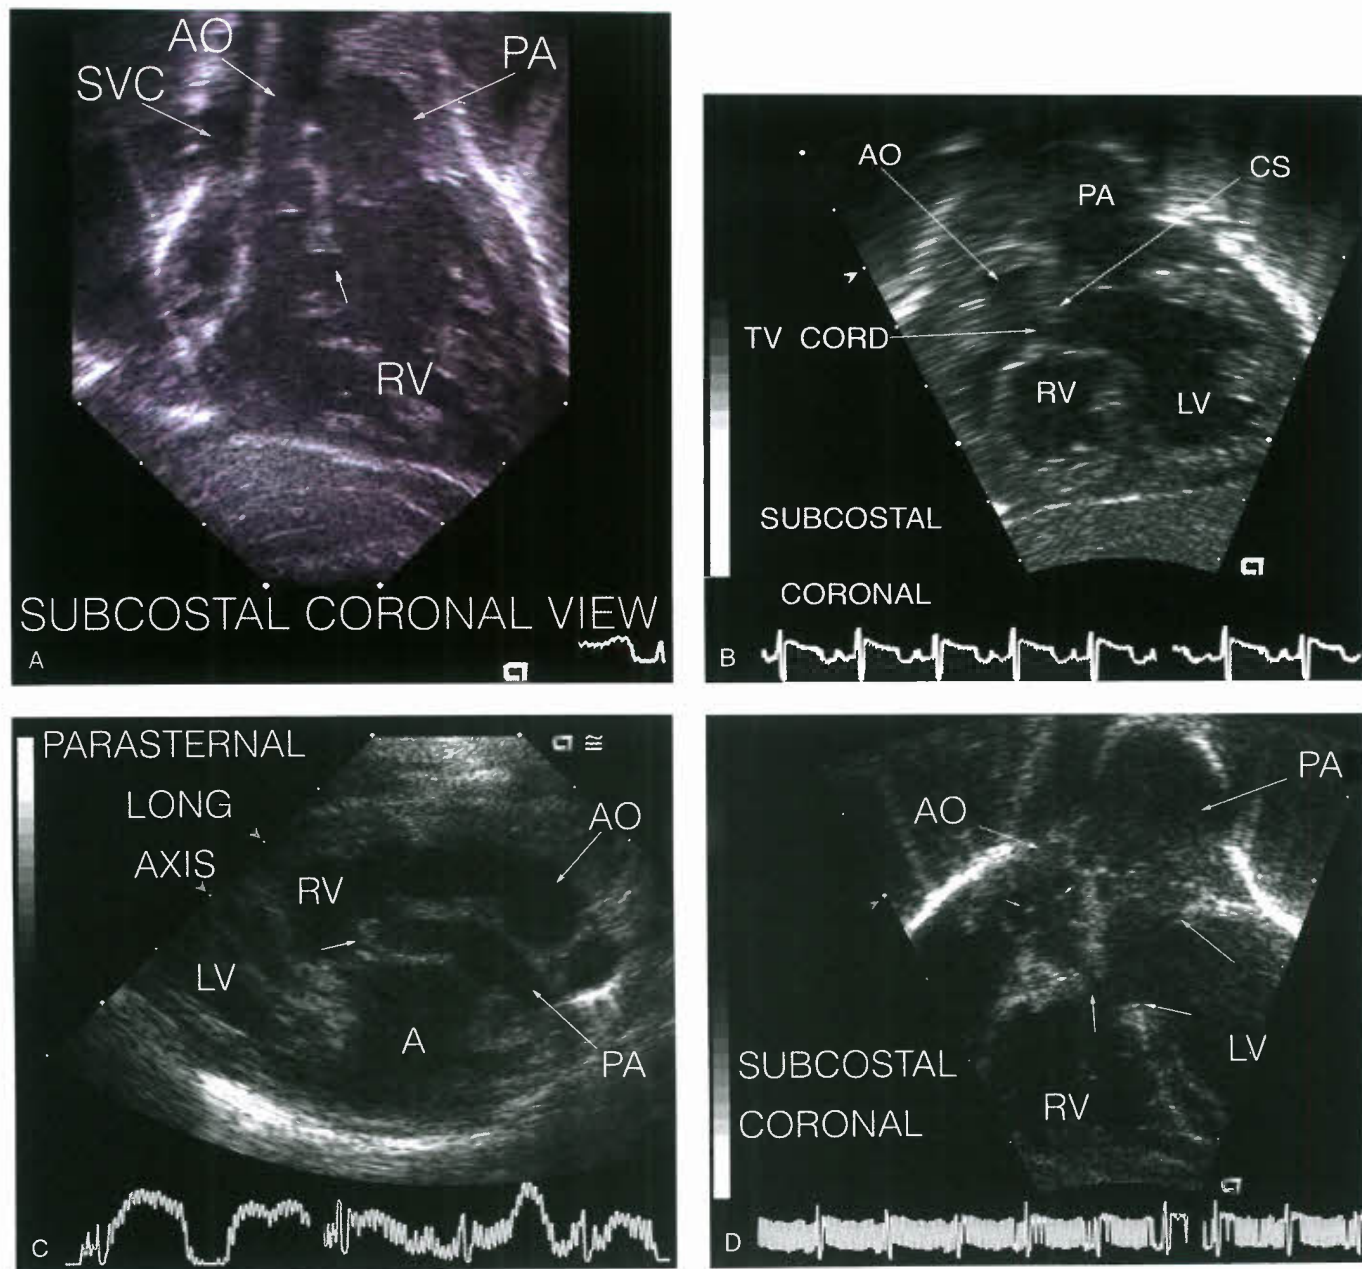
Echocardiographic views of anatomy in “transposition type.” A: Subcostal coronal view: Aorta and pulmonary artery both arise from the RV and are side-by-side in the same plane with the aorta rightward. Relatively large subaortic conus (*small arrow*) separates the aorta and pulmonary artery. Aortic valve and ascending aorta are hypoplastic. SVC, superior vena cava; AO, aorta; PA, pulmonary artery; RV, right ventricle. B: Subcostal coronal view: Aorta and pulmonary artery both arise from the RV with the aorta rightward and slightly anterior. Large subaortic conus separates the aorta and pulmonary artery with narrowing of the egress from the LV due to the conal septum and tricuspid valve cordal attachments. RV, right ventricle; LV, left ventricle; PA, pulmonary artery; AO, aorta; CS, conal septum; TV cord, tricuspid valve cordal attachment. C: Parasternal long axis view: Aorta and pulmonary artery both arise from the RV with the aorta rightward and anterior. There is tissue beneath the pulmonary valve (*small arrow*); due to this subvalvar obstruction, the pulmonary artery is relatively small compared to the aorta. RV, right ventricle; LV, left ventricle; AO, aorta; PA, Pulmonary artery; A, atrium. D: Subcostal coronal view: Aorta and pulmonary artery both arise from the RV, side-by-side, in the same plane with the aorta rightward. Aortic valve leaflet tips marked with small arrows. Note subaortic obstruction due to large subaortic conus (*vertical arrow*). Due to the subaortic obstruction, the aortic valve and ascending aorta are relatively hypoplastic. VSD demarcated by arrows at the crest of the interventricular septum and at the small rim of conal septum beneath the pulmonary valve. RV, right ventricle; LV, left ventricle; AO, aortic valve; PA, pulmonary artery.
